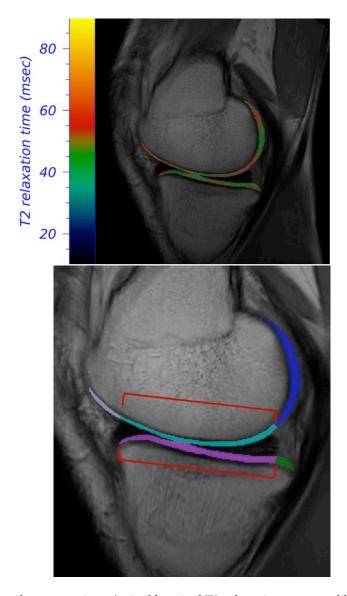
MRI of a participant demonstrating: a) pixel by pixel T2 relaxation map, and b) articular cartilage regions of interest (teal is weightbearing portion of femoral cartilage, pink is weightbearing portion of tibial cartilage).
